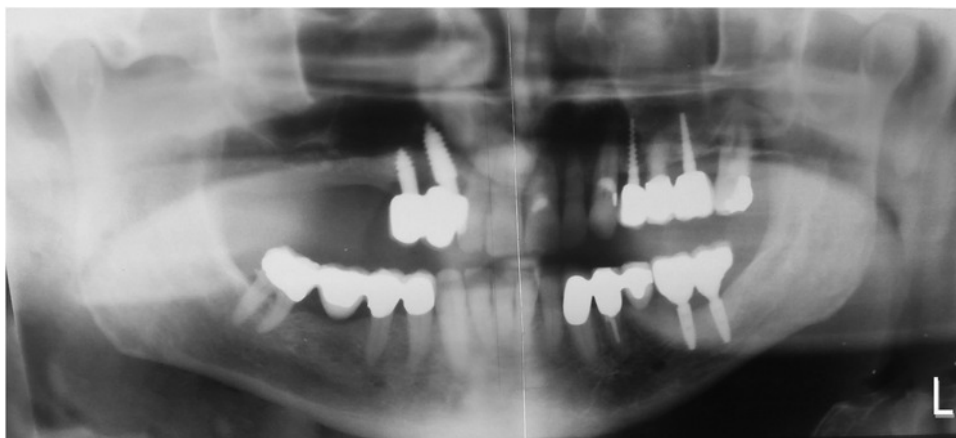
Antemortem panoramic radiograph performed in October 2014.
